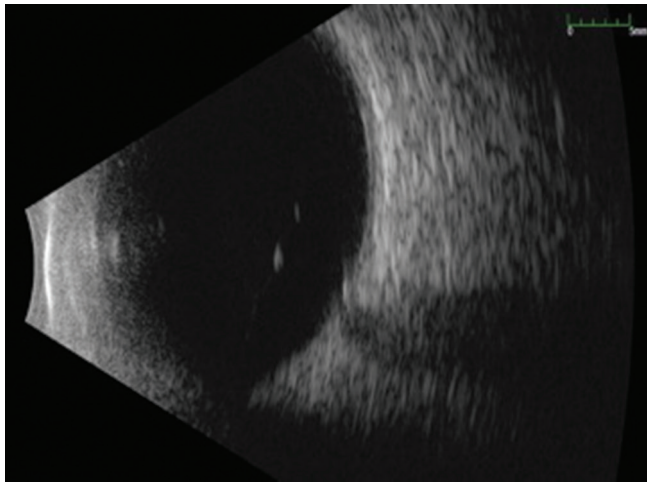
B-scan ocular ultrasound of the right eye after 6 months, compared to the first presentation [Figure 2a], showed the disappearance of the posterior choroidal thickening and of the areas of exudative retinal detachment
